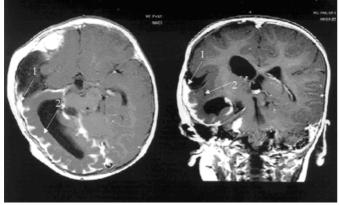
Magnetic Resonance Image, with gadolinium injection (i.v. 0.2 ml/kg). T1-weighted images, with an axial slice on the left and a coronal slice on the right. A cortical vascular enhancement is seen on the temporal lobe (arrow 1) what suggests veno-capillary hemangioma over a thick dysplastic cortex (arrow 2).
